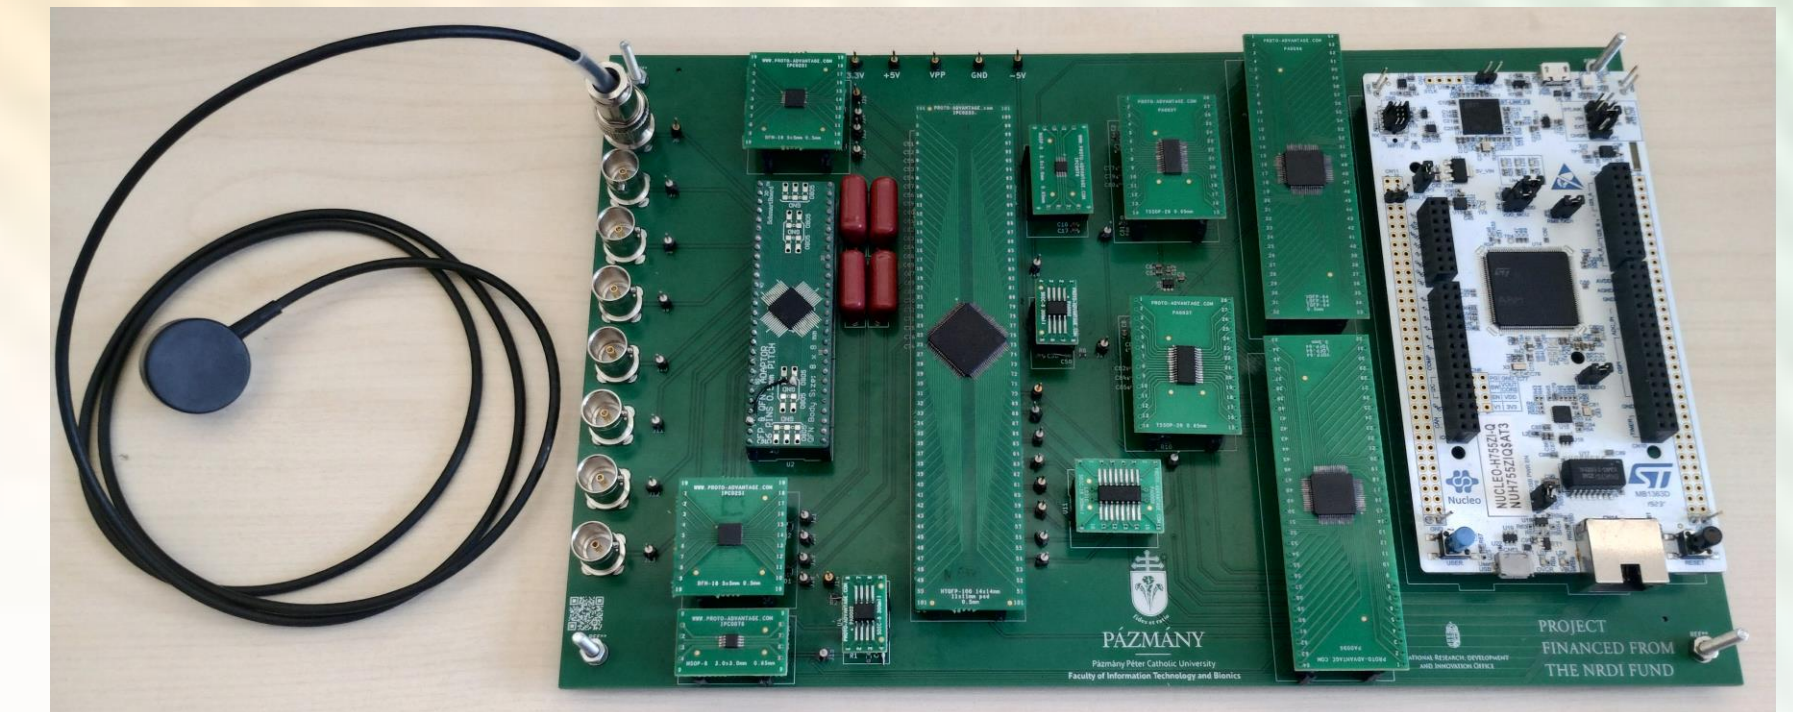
8-channel, amplitude-mode ultrasound
